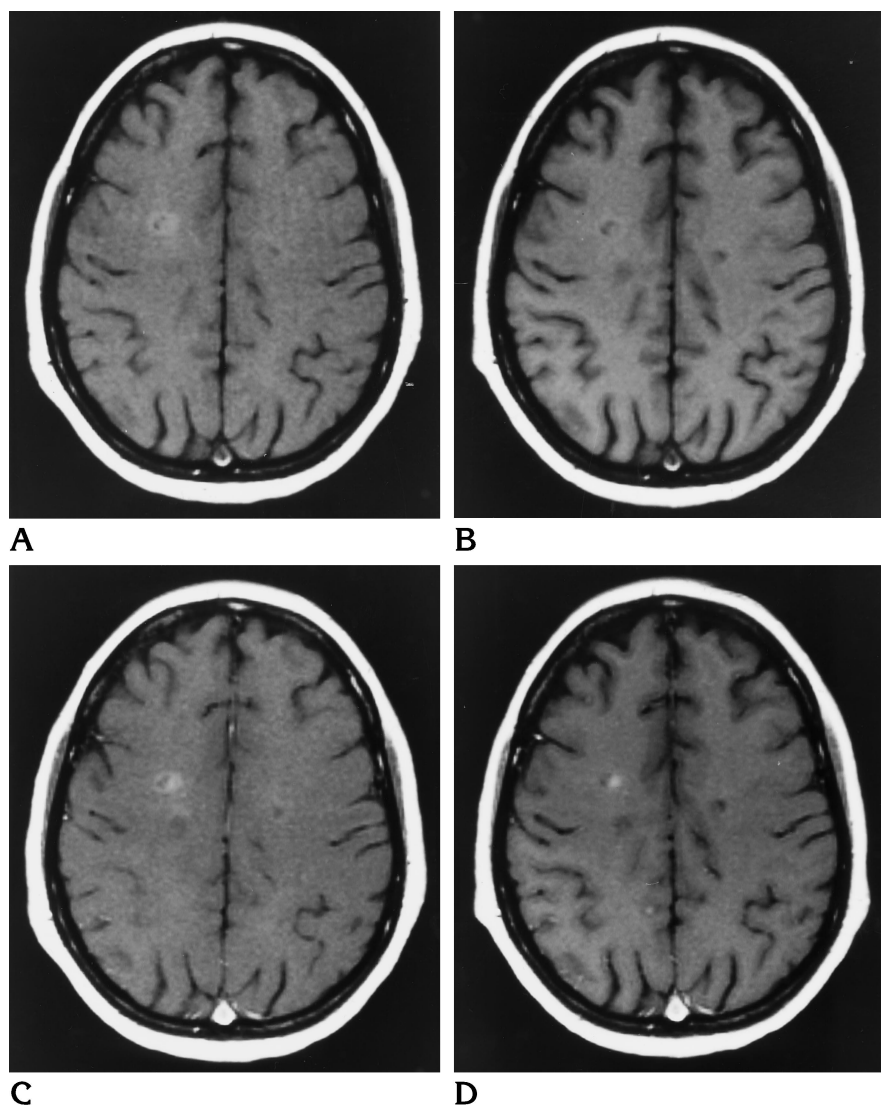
Unenhanced T1-weighted image with MTC (A) versus unenhanced T1-weighted image without MTC (B), and single-dose MTC contrast-enhanced T1-weighted image (C) versus triple-dose contrast-enhanced T1-weighted image (D) obtained 17 minutes after gadolinium administration. Note the hyperintense signal surrounding the hypointense lesion on the unenhanced T1-weighted image with MTC, which interfered with the detection of enhancement; both readers interpreted this exam as inactive, and both detected an enhancing lesion on the triple-dose gadolinium image, which changed this exam from "inactive" to "active."
